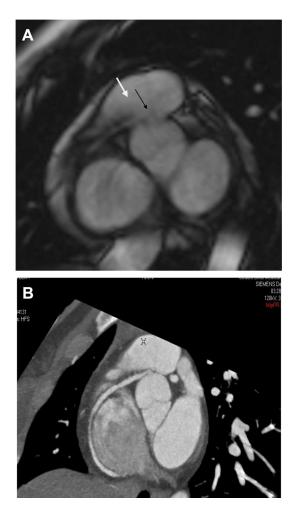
Case example 1. (A) Stress cardiac magnetic resonance imaging cine imaging in the basal short axis suggested the presence of anomalous origin of the right coronary artery from the left coronary sinus with course between the aortic root and the right ventricular outflow tract (*black arrow*). (B) This congenital abnormality was subsequently confirmed by coronary computed tomography angiography.
